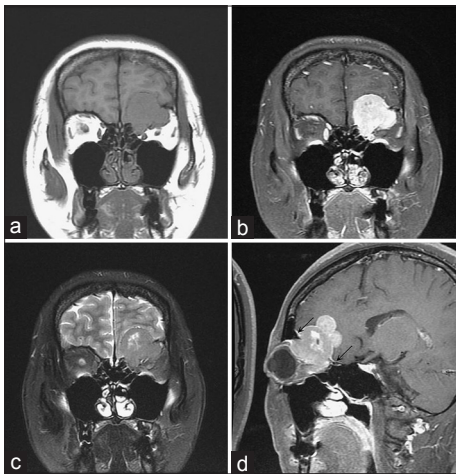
Preoperative orbit MRI. Coronal T1 weighted image (a), coronal T1 weighted image post gadolinium enhancement (b), coronal T2 weighted image (c), and sagittal T1 weighted image post gadolinium enhancement (d) showing a well-circumscribed lesion isointensity on T1-weighted images and hypointensity on T2-weighted image with good enhancement and has small cystic/necrotic change noted in the left frontal base, orbital roof, and upper-medial orbital region. The black arrows point out the dural tail sign
